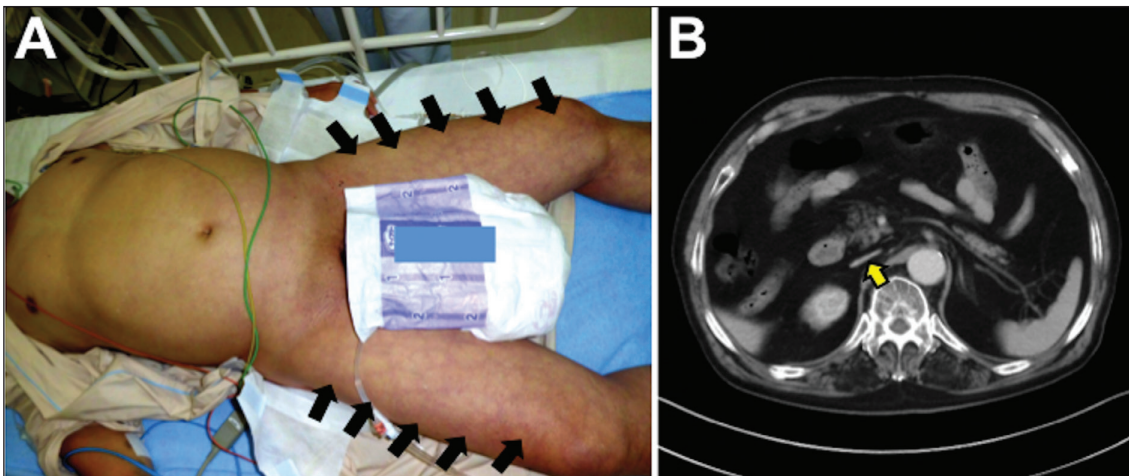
(A) Marked venous congestion (arrows) appeared only in the patient's lower body. (B) Computed tomography showing the collapsed IVC (arrow). IVC, inferior vena cava.
